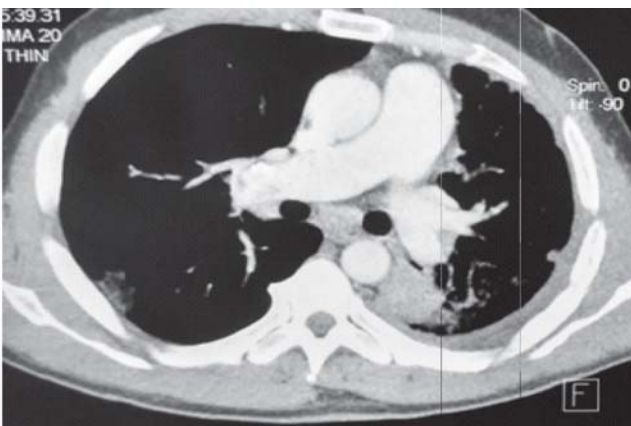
Contrast-enhanced computed tomography of thorax showing filling defects in the right main pulmonary artery.
